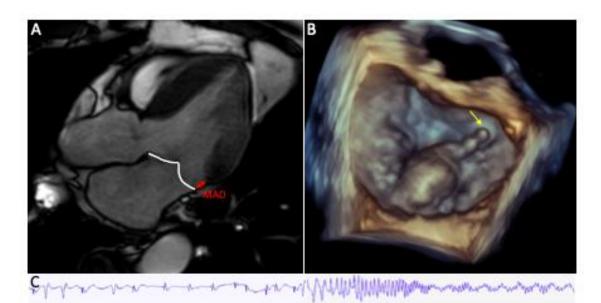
Ventricular fibrillation registered on a loop recorder in a study patient with MAD and MVP. A) Cardiac magnetic resonances showing mitral annulus disjunction (red). B) 3D echocardiographic image showing mitral valve prolapse. C) Ventricular fibrillation detected by implantable loop recorder (Reveal LINQ, Medtronic).
